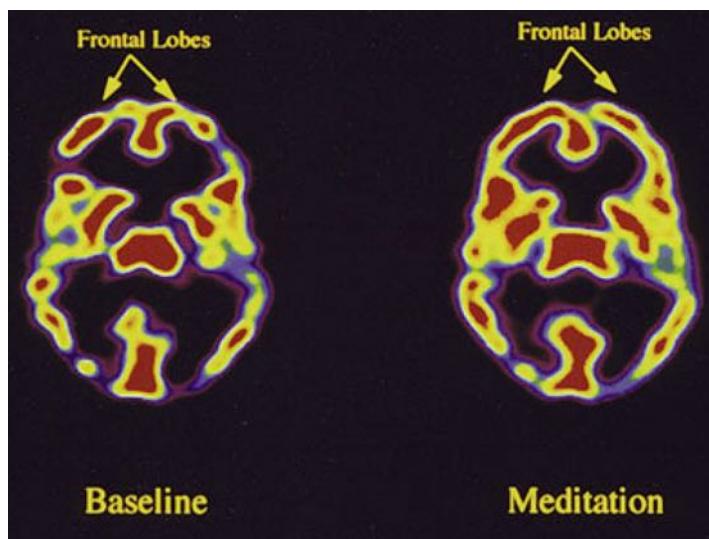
SPECT Scan of a Tibetan Buddhist monk at baseline and during meditation. From Newberg, University of Pennsylvania Health System. There was increased activity in the prefrontal lobes during meditation reflecting increased concentration. Reproduced with permission of the authors and publisher from: Newberg, A. Pourdehnad, M. Alavi, A. & d’Aquili, E. G. Cerebral blood flow during meditative prayer: preliminary findings and methodological issues. *Perceptual and Motor Skills*. 97: 625-630, 2003.
